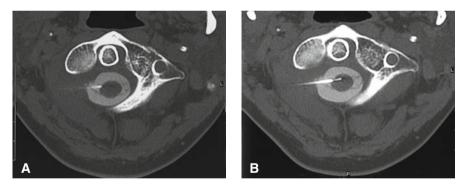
A Final position of the cannula in axial CT slices (right side) in percutaneous cordotomy. B Final position of the electrode, anteromedial section of the target, in axial CT slices in percutaneous cordotomy
